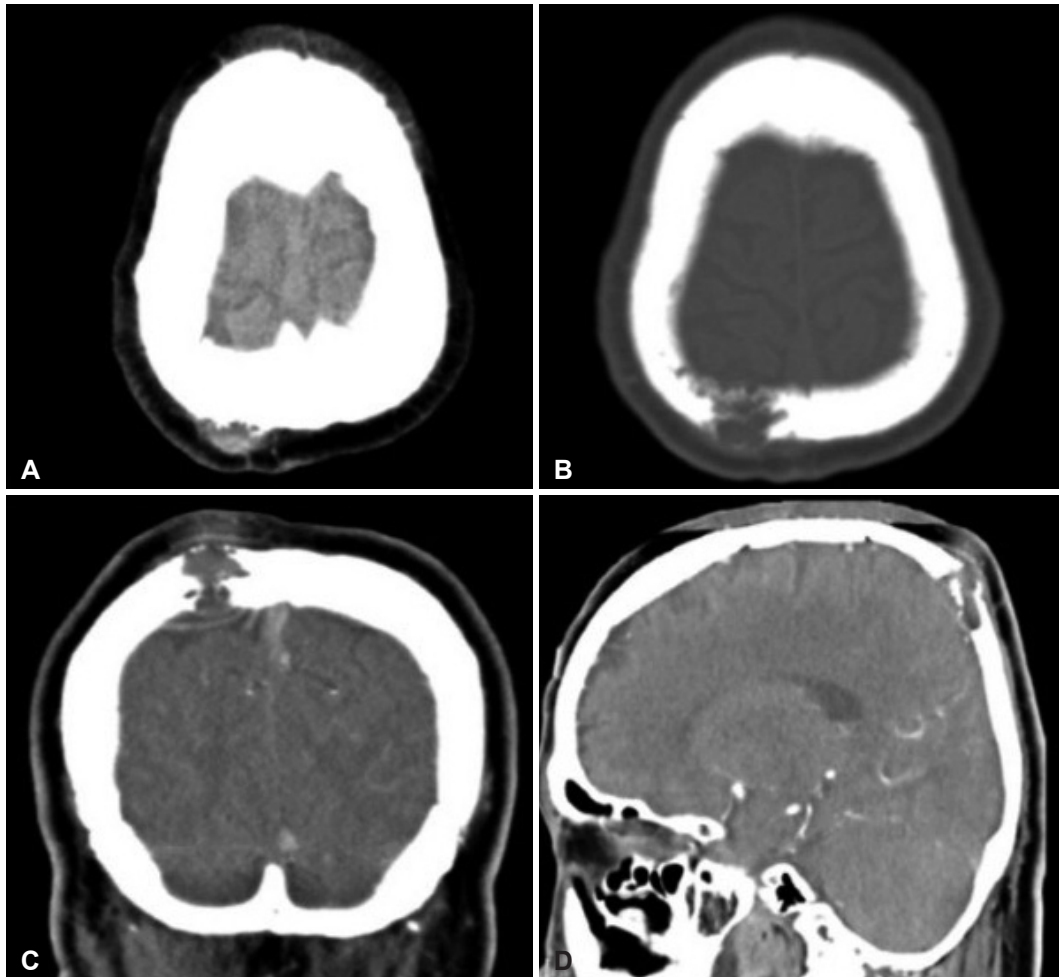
Initial brain CT. CT scan (A) shows a right-sided superior parietal mass expanding the calvaria. Bone window CT (B) demonstrates a bony destruction. C and D reveal a well-defined, enhancing soft tissue mass in right parietal bone.
